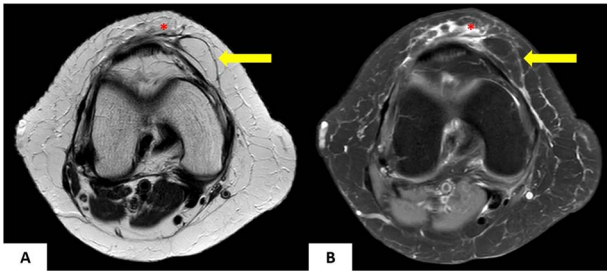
Axial T2-weighted (A) and fat suppressed axial proton density-weighted (B) images show an encapsulated fatty lesion (arrow) at the anterior aspect of the medial patellofemoral ligament. It shows hyperintensity on the T2-weighted image and hypointensity on the fat-suppressed axial proton density-weighted image. Ill-defined subcutaneous fat edema (asterisks) is seen around the lesion, predominant at the anterior aspect.
